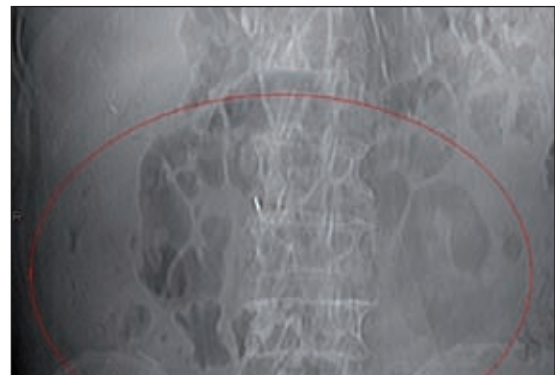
Chest-abdominal X-ray confirming the appropriate diagnosis.
